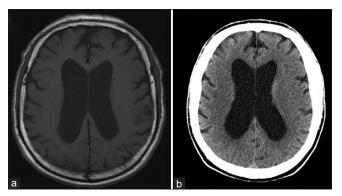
Preoperative T1-weighted non-contrast axial magnetic resonance imaging (a) and non-contrast axial computed tomography (b) demonstrating prominent lateral ventricles out of proportion to degree of cortical sulcal markings suggestive of hydrocephalus.
